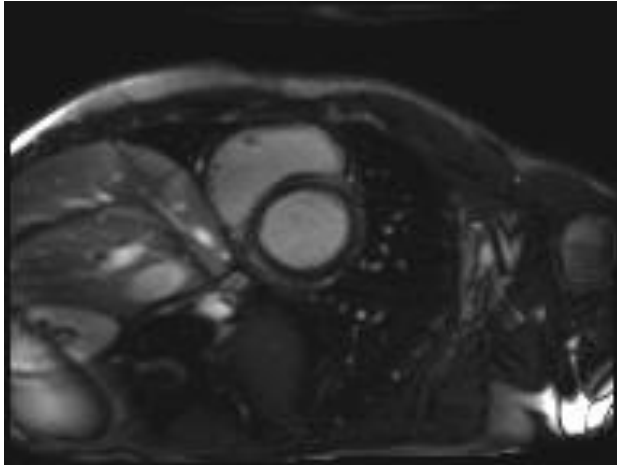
Cardiac MRI showing signs of late gadolinium enhancement
